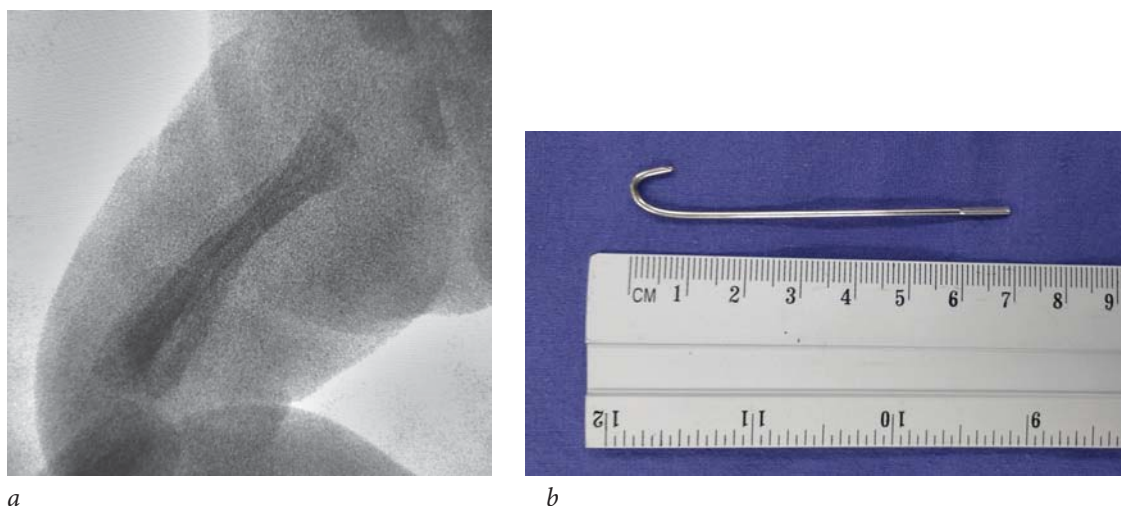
X-rays of the right femur after removal of the intramedullar wire (a). The wire removed (b)
